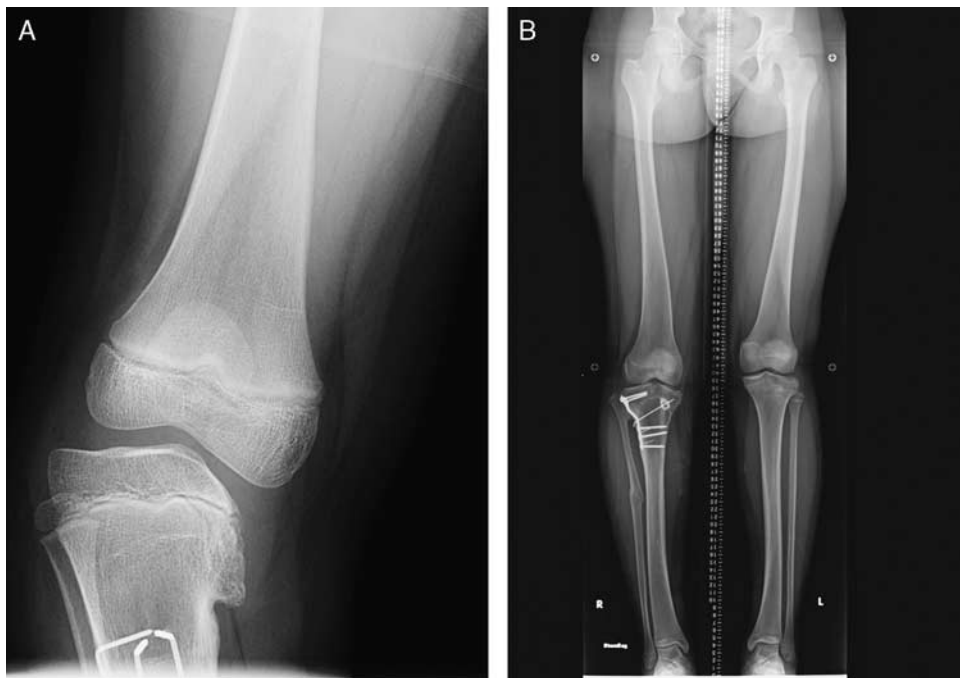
Case 7, unilateral case, (A) preoperative anterior posterior radiograph right tibia. (B) postoperative MAA radiograph 5 years after contralateral epiphyseodesis of proximal tibial growth plate. The MAA corrected to 0 degrees and the limb length discrepancy is reduced to 8 mm.
